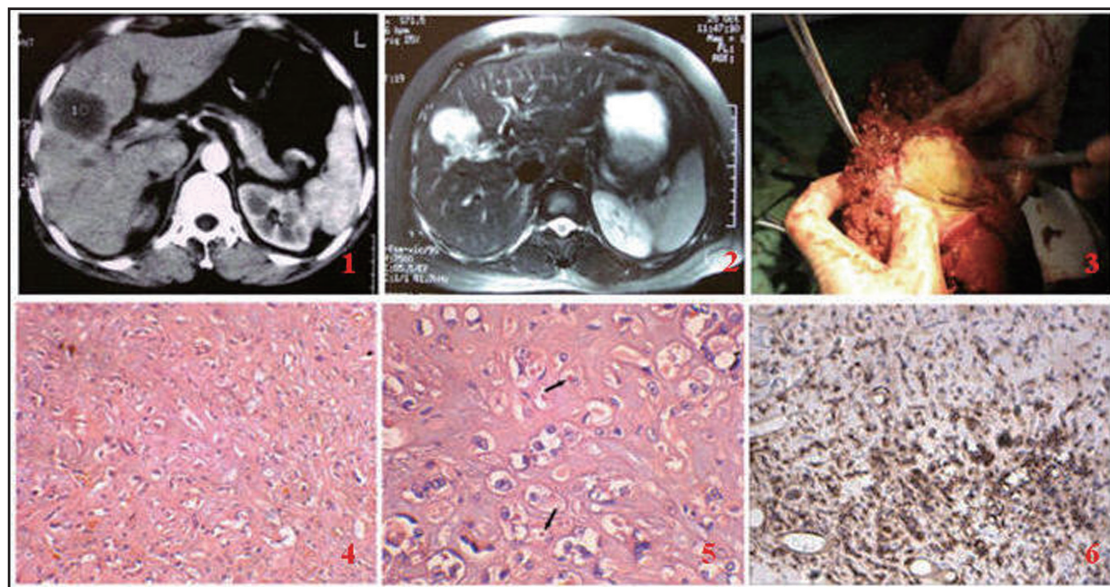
Spiral CT examination of the liver performed after administration of intravenous contrast medium (arterial phase) shows several hypodense lesions with a non-obviously peripheral enhanced rim.
